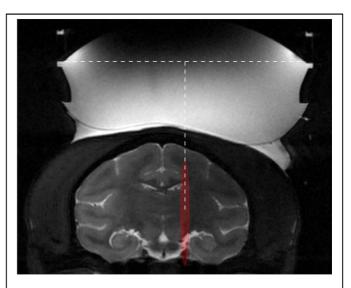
Example of target planning and acoustic coupling verification on T_2 -w MR images. The target planning was performed by tracing a normal incidence (white dashed line) of the focus (in red) based on the transducer geometry and calibrations in free water.
